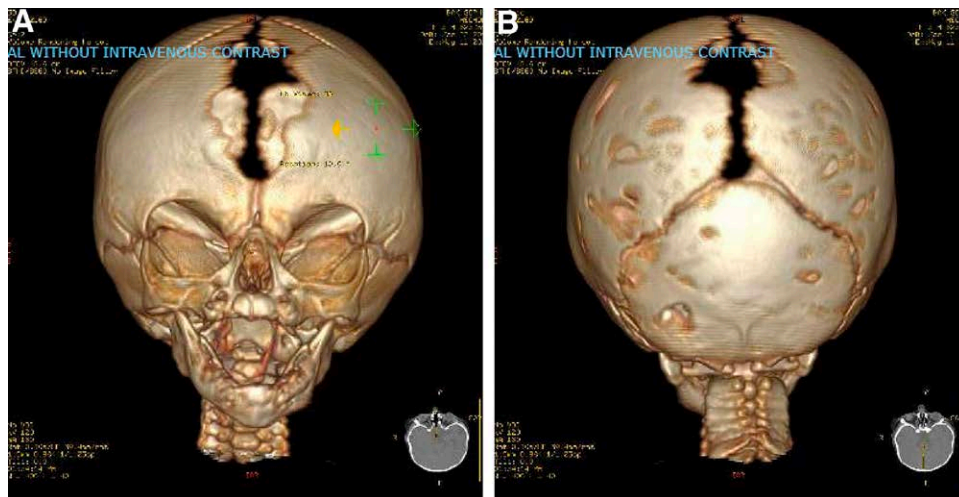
Three-dimensional reconstruction images from patient CT scan demonstrating hyperdilatation of metopic and sagittal sutures. A, Frontal view. B, Rear view.
